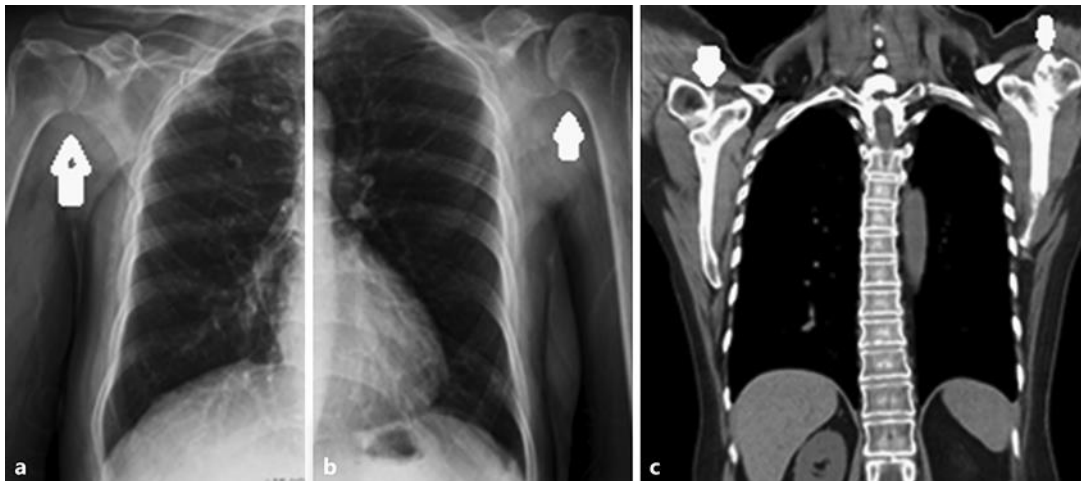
Shoulder lesions of case 1. The plain X-ray revealed osteonecrosis of the right humeral head (arrow) (a) and the left humeral head (arrow) (b). c The chest CT scan (coronary view) showed bilateral osteonecrosis of the humeral heads (arrows), which was more severe on the left side.
